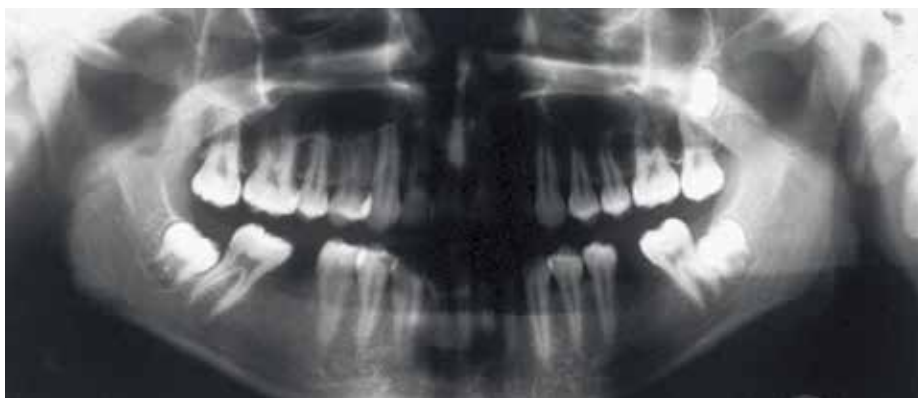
Case 1: orthopantomogram
